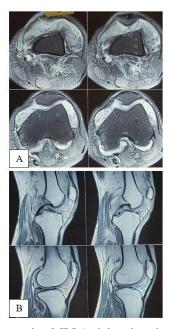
Preoperative MRI (axial and sagittal) of left knee joint – features suggestive of PVNS)
